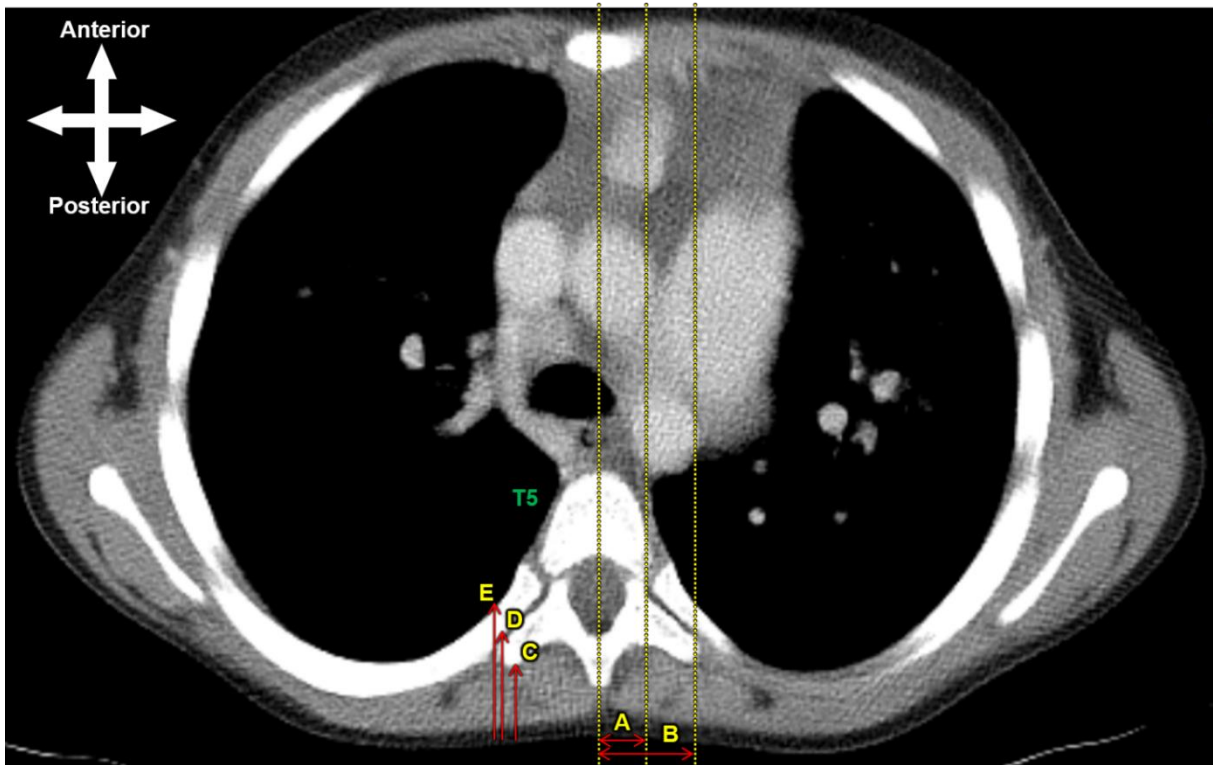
An axial thoracic CT image at vertebral level T5. Measurements included: A – the distance from the spinous process to the hypothetical needle insertion site; B – the distance from the spinous process to the lateral tip of the transverse process; C – the depth from the skin to the transverse process; D – the depth from the skin to the paravertebral space; E – the depth from the skin to the anterior border of the rib.
